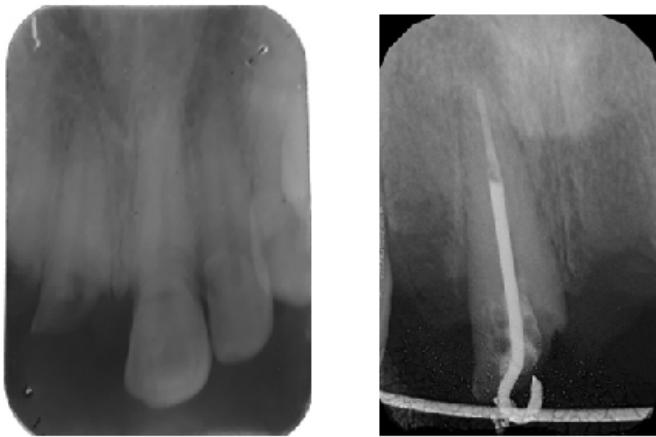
(a) Diagnostic radiograph showing the fractured crown (b) Radiograph after placement of J Hook in prepared post space and anchorage bar
